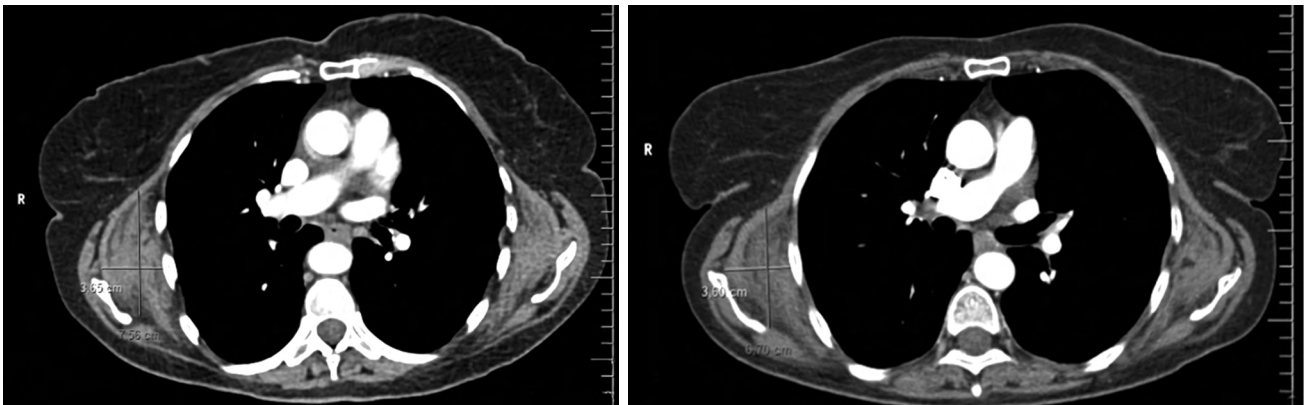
Thorax computed tomography; years 2015 vs. 2018.
